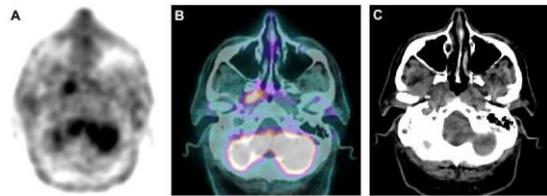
Axial PET/CT. A, B, C images show increased uptake involving the left lateral wall and fossa of Rosenmüller without cervical lymph node uptake). SUVmax: 6.7
